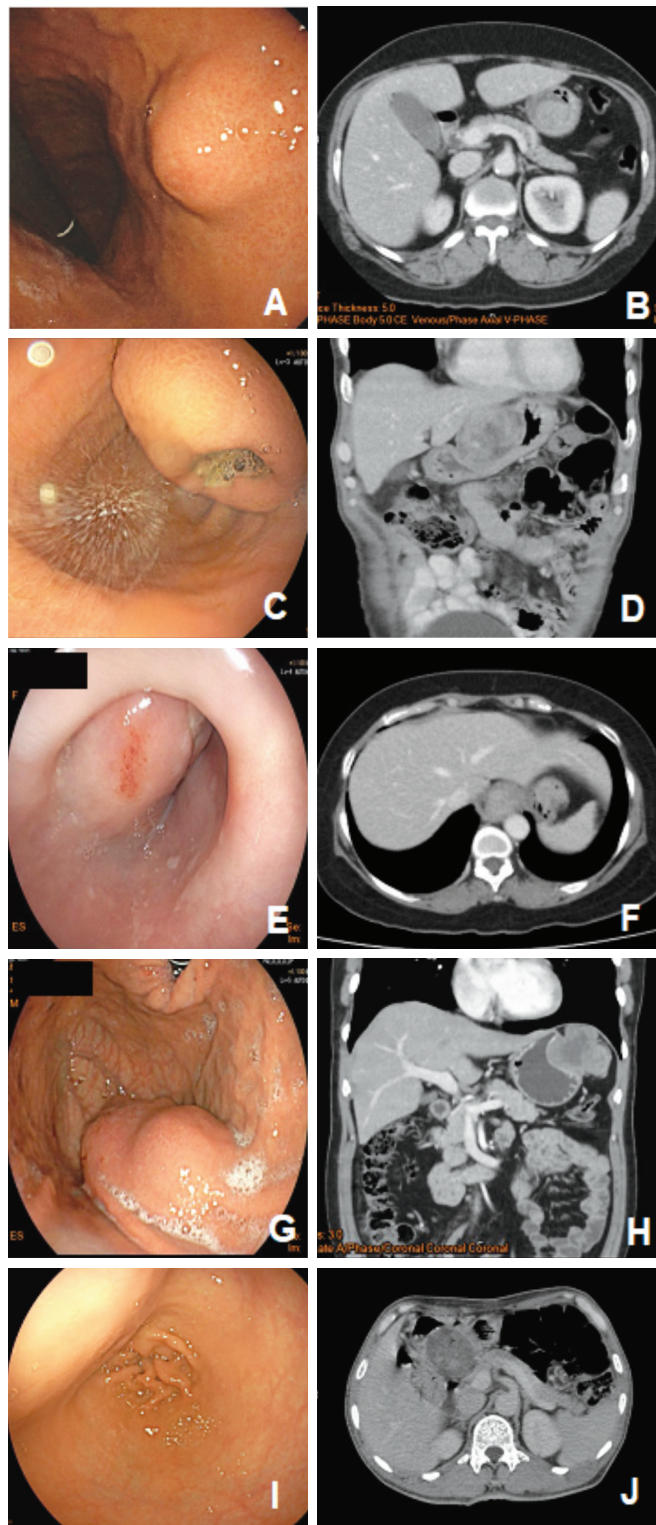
Shows the endoscopic findings and computed tomography (CT) scans of submucosal lesions on the posterior wall of the stomach, lesser curvature, esophagogastric junction (EGJ), cardia, and pyloric ring of the antrum.
